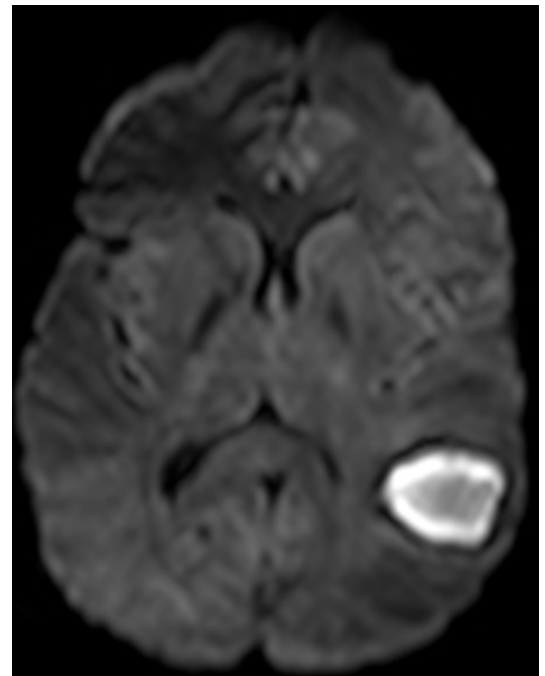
Axial brain diffusion-weighted image (DWI) of resolving hematoma. *Courtesy of Jacqueline Bello, MD, FACR, Montefiore Medical Center.*
